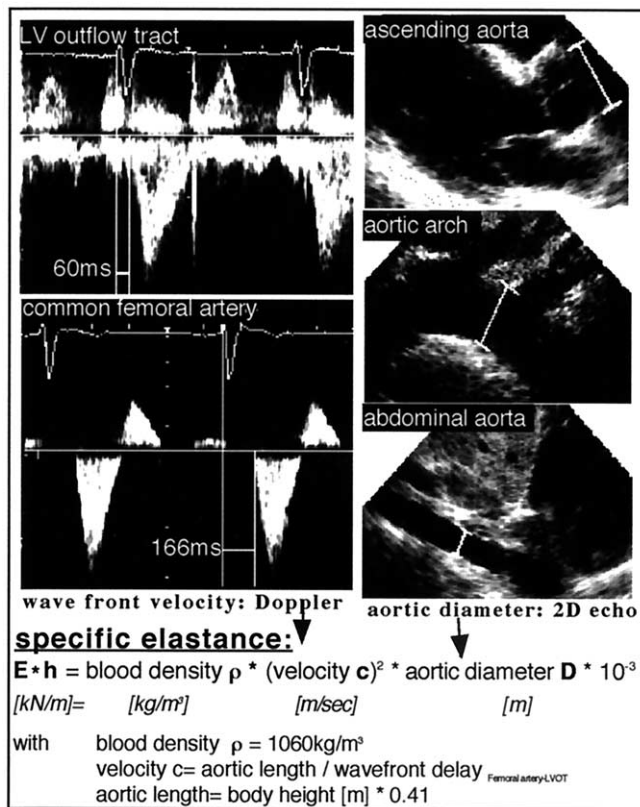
Method for determination of specific aortic elastance by trans-thoracic echocardiography: Wave front propagation time from the left ventricular outflow tract to the common femoral artery is measured using pulsed wave Doppler. The wave front is defined as the extrapolation of the first segment of the Doppler flow profile to the baseline. Average aortic diameter is determined from measurements in the ascending aorta, the aortic arch and the abdominal aorta. All measurements are made using a conventional echocardiograph.
